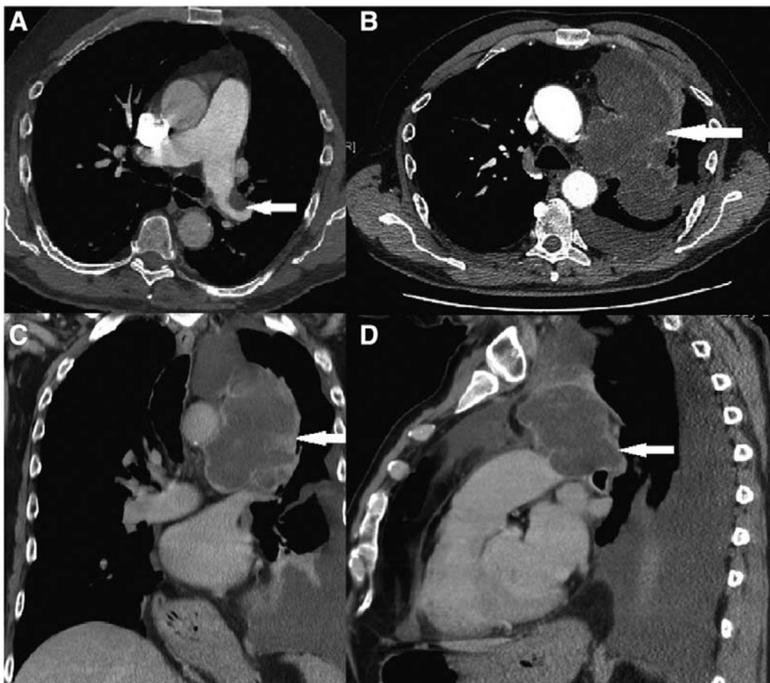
A, Computed tomographic scan (CT)-chest (with contrast) showing a filling defect in the left main pulmonary artery (arrow), (B), CT scan-chest (with contrast) a year later showing large left mediastinal mass (arrow), (C), CT scan-chest (with contrast), coronal reconstruction showing large mediastinal tumor (arrow), (D), CT scan chest (with contrast), sagittal reconstruction showing the same tumor originating from the pulmonary artery (arrow).
